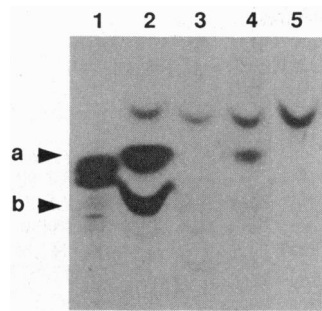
Incorporation of [^3H]GlcNAc in cell-free extracts of LCL cells shown after prolonged exposure (35 days) of the x-ray film to the TLC plate. Lane 1, trypanosome membranes; lane 2, normal LCL (HH16/5N); lane 3, PNH type III LCL (HH16/7P); lanes 4 and 5, PNH type II LCLs (HH18/8P and HH17/42P, respectively). HH16/7P and HH17/42P incorporate no detectable GlcNAc, whereas HH18/8P incorporates greatly reduced amounts of GlcNAc.
